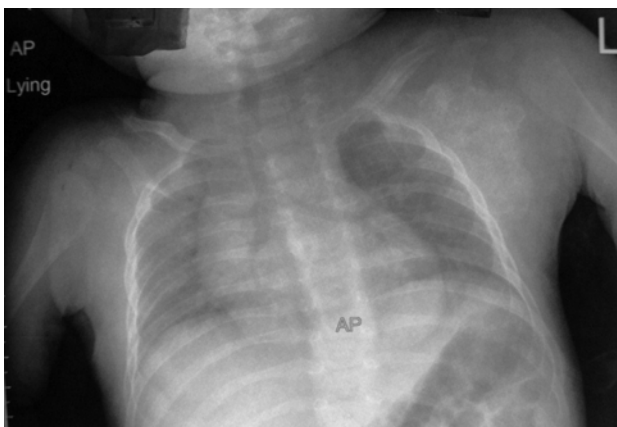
Initial anteroposterior radiograph of the chest and both shoulders shows destruction of the glenoid and the lateral border of the scapula.
